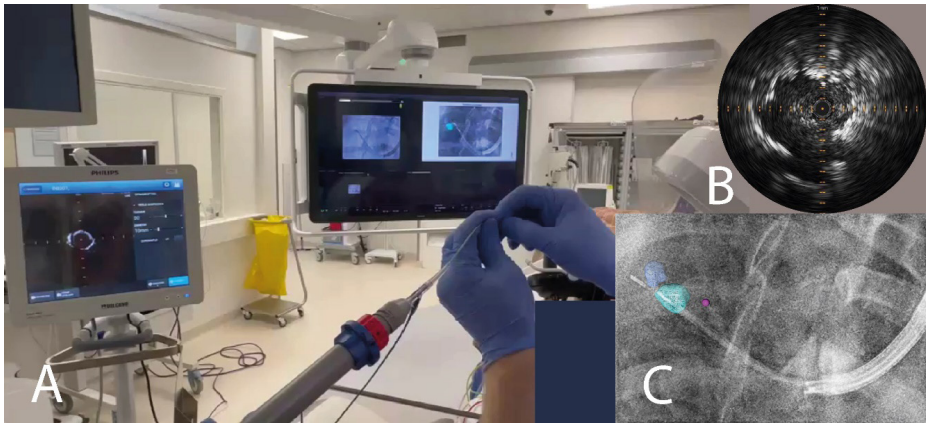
Visualization of the Pioneer Plus catheter in patient. (A) with a view of the radial US image (B) and augmented fluoroscopy (C) in a suite equipped with a Philips Azurion Flexarm CBCT system. Augmented fluoroscopy depicts two parts of the lesion in dark and light blue and a pink dot for the catheter position on CBCT, used for navigation and sampling. The US transducer (distal) and needle shaft (proximal) can be seen as radiopaque in image C. CBCT, cone beam computed tomography; US, ultrasound.
